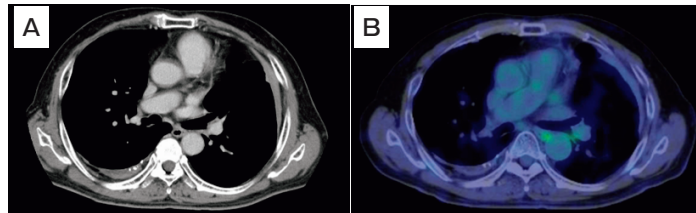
Post-chemotherapy radiological examinations. (A) A contrast-enhanced chest CT image showed significant tumor shrinkage. (B) 18F-FDG PET/CT revealed a metabolic response in the tumor (SUVmax=2.1)
